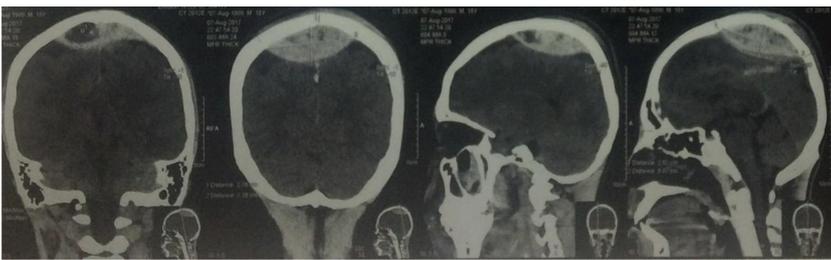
Coronal and sagittal view of brain CT Scan showing evidence of VEDHs with the volume of 76 ml (2.76 cm x 7.89 cm x 6.74 cm in size)
